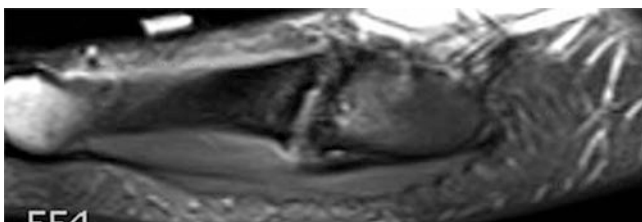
T1 weighted MRI (sagittal and transverse) shows nonunited Jones fracture
